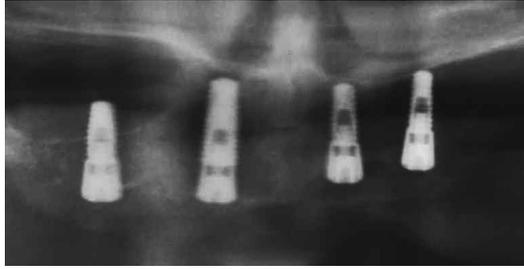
Panoramic radiographic view following the placement of 4 endosseous osseointegrated implants.
